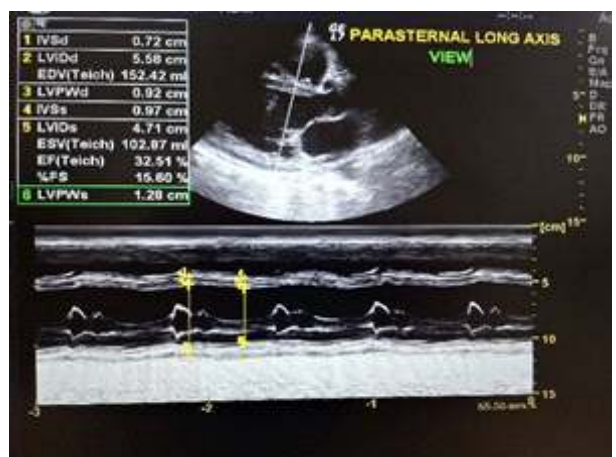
Right Parasternal Long Axis View showing CCF
